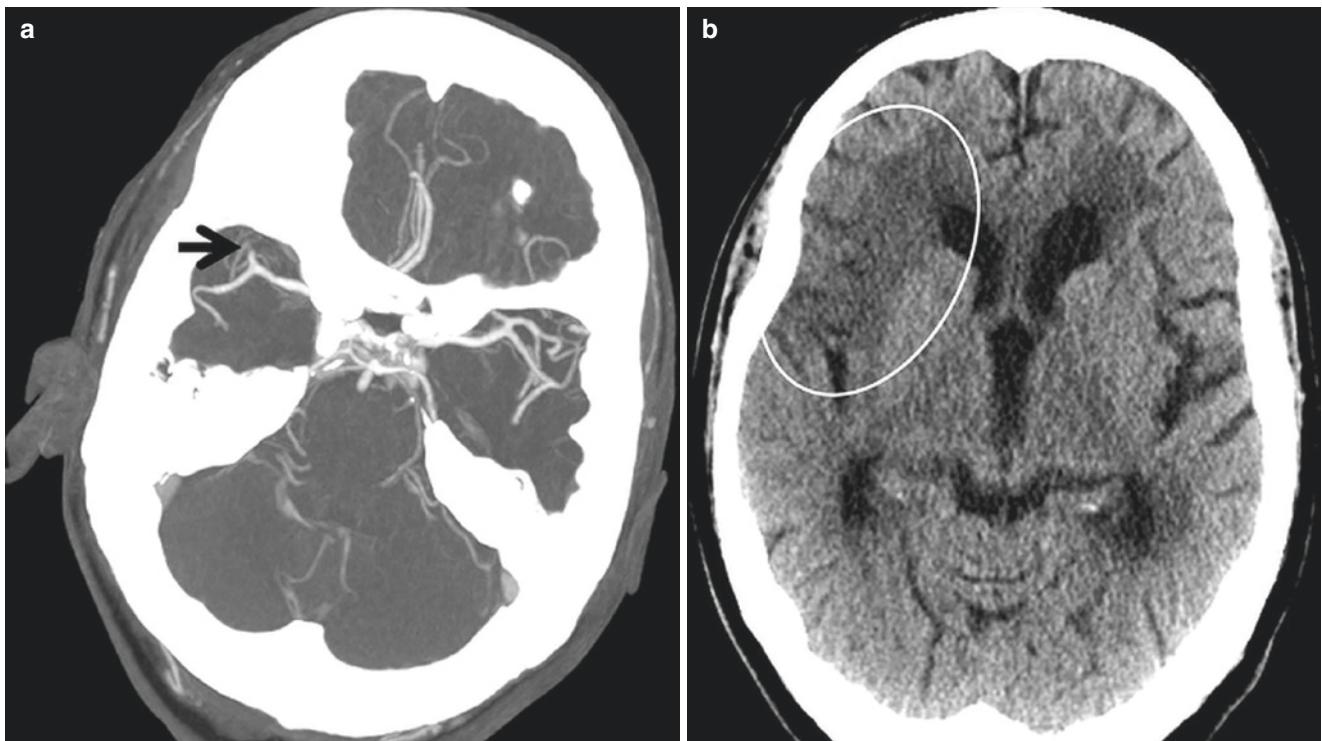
MCA superior division infarction. Axial CTA MIP (a) shows occlusion of superior/anterior M2 division of the right MCA at the origin (*arrow*). (b), Subsequent NCCT demonstrates acute infarction in the right anterior insula and frontal operculum (*circle*)
